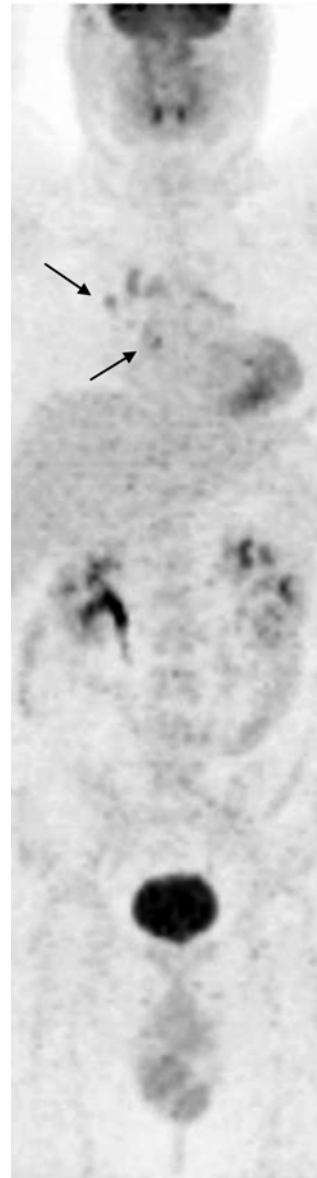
PET/CT remained positive after IGEV salvage chemotherapy
